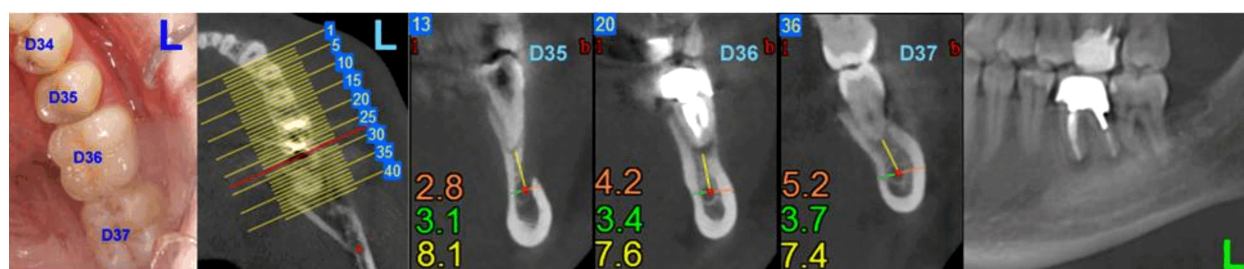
CBCT: left hemi-mandible. Bucco-lingual sections at the level of teeth 3.5, 3.6, 3.7. Orange – MC-BS distance; yellow – MC-T distance; green – MC-LS distance. CBCT: Cone-beam computed tomography; MC-BS distance: Distance between the mandibular canal and the buccal (lateral) surface of the mandible; MC-T distance: Distance between the mandibular canal and the root apices of the second premolar, the first and second molars; MC-LS distance: Distance between the mandibular canal and the lingual (medial) surface of the mandible.
